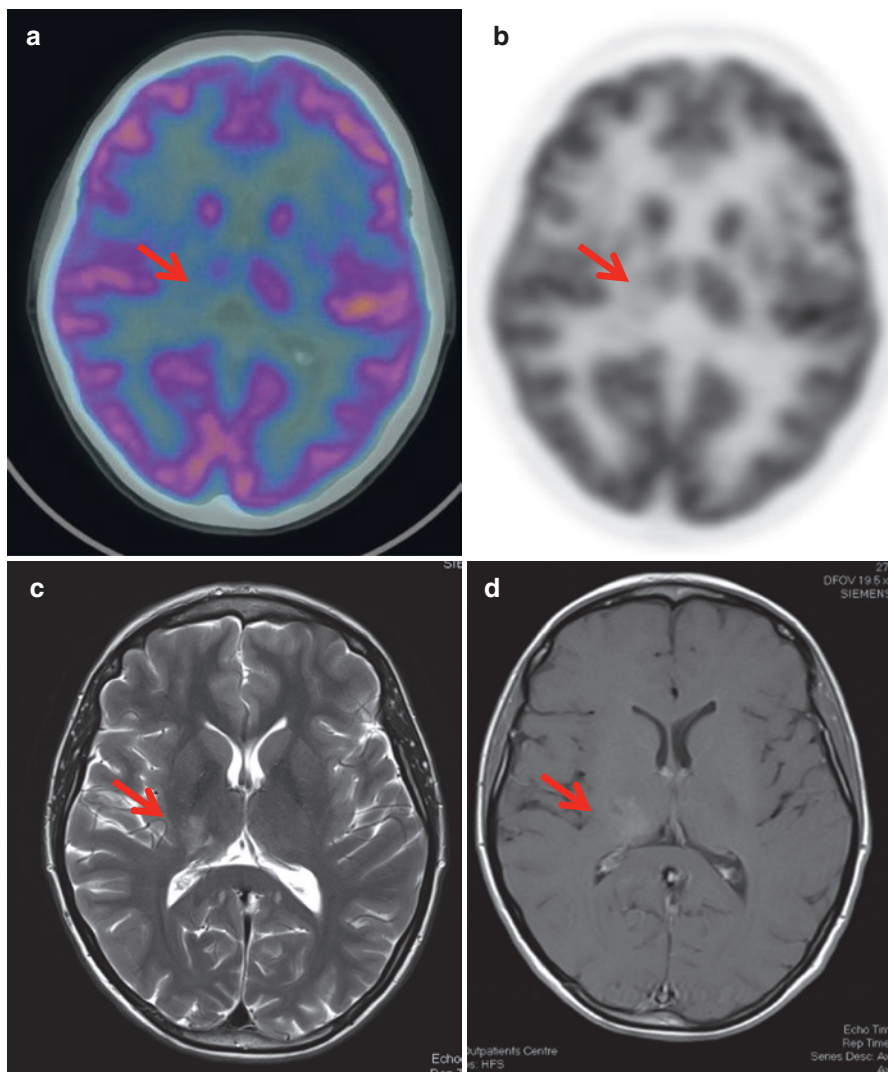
(a–d) Axial fused ^{18}F FDG PET/CT (a), axial ^{18}F FDG PET (b), axial T2WI (c) and post-contrast T1WI (d) show area of focal reduction of tracer uptake in the right thalamus (a, b, arrows) which correspond to an area of high T2 signal and mild enhancement on MRI (c, d arrows) in a patient with multiple sclerosis.
